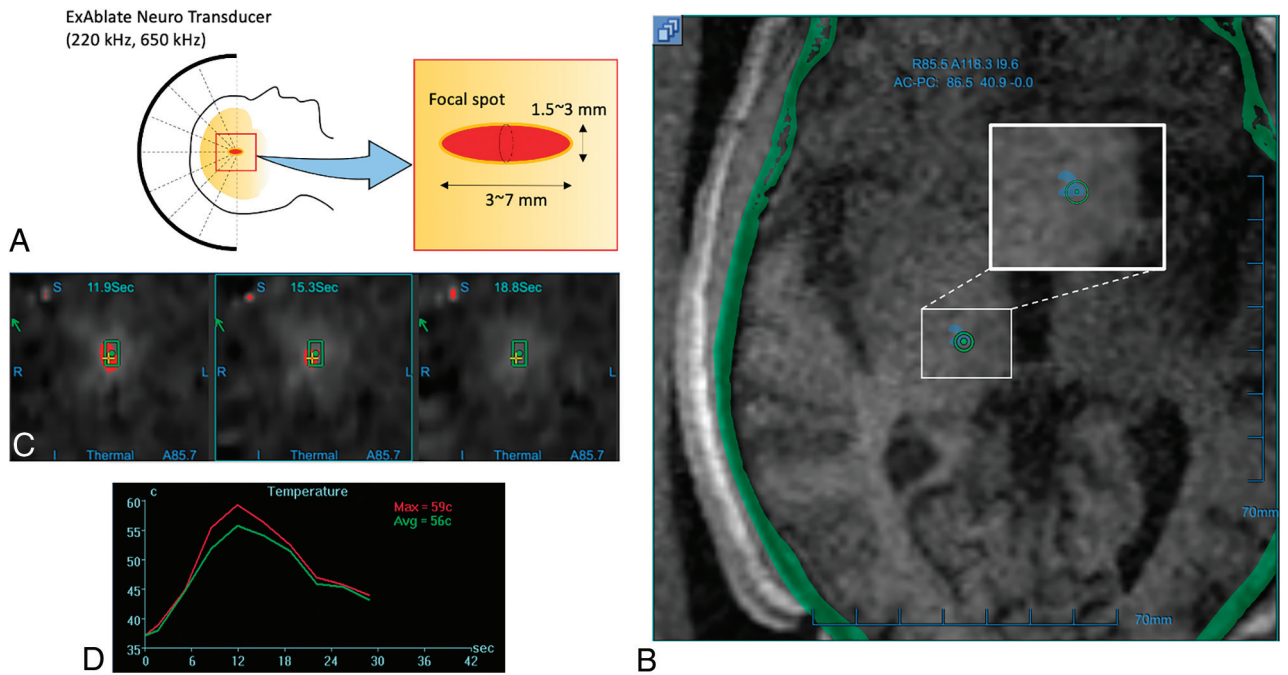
MR imaging thermometry during transcranial focused ultrasound. A, The focal spot of the ExAblate Neuro transducer takes a prolate ellipsoid shape, measuring approximately 1.5 mm in diameter and 3 mm in length at 650 kHz and approximately 3 mm in diameter and 7 mm in length at 220 kHz. B, The PRF thermal dose map shows an accumulated thermal dose in light blue, which is based on the CEM43 model. The thermal dose map visualizes the amount of heat deposited into the target tissue, allowing clinicians to optimize treatment parameters and positioning while minimizing the risk of normal tissue damage. C, Multiple MRT images are obtained during sonication. In this example, images are acquired at 11.9 seconds (*left panel*), 15.3 seconds (*middle panel*), and 18.8 seconds (*right panel*) after the sonication has begun, generating images of tissue temperature at the focal spot according to a user-determined color scale. The time intervals between images will vary depending on the user-determined settings, such as the addition of presonation baseline phases or changing from multiple- to single-echo thermometry. The duration of the sonication is often set so that peak temperatures are achieved in sync with the MRT acquisition. The alignment of the focal spot to the target is best assessed in the phase-encoding direction. D, After sonication, a temperature graph is generated to show average and maximal temperatures across time within the ROI. Avg indicates average; Max, maximum.
